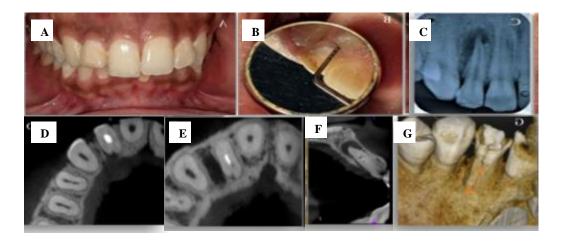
(A) Clinical photograph of tooth#10 showing multiple fracture lines and discolouration (B)Palatal view showing localised probing pocket depth of 7mm (C)The periapical radiograph of #10 showing periapical radioluency and bone defect (D-F) CBCT axial cross sections showing that the palatogingival groove is concomitant with the periodontal lesion, but it is not connected to the pulp space. The endodontic and periodontal lesions are independent (G) 3D-CBCT showing depth and extent of palatogingival groove.
